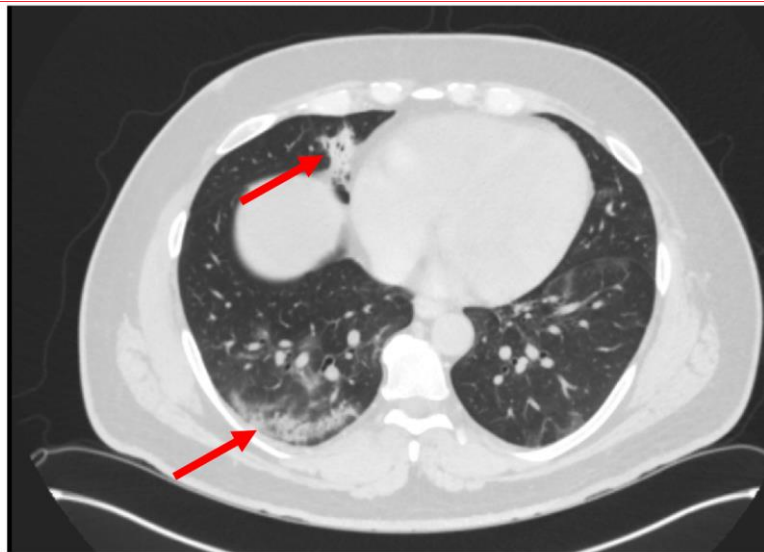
Computed tomography of patient with GGO in the posterior right lower lobe and consolidation in the right middle lobe (i.e. arrow).
